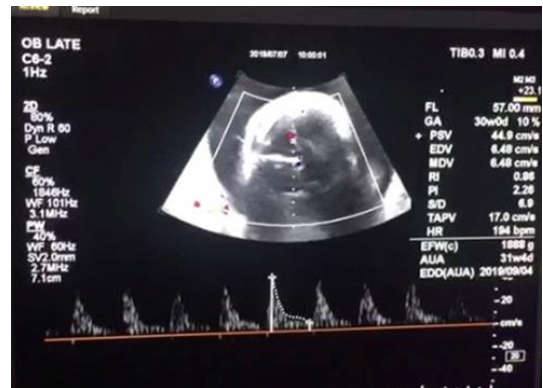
The middle cerebral artery Doppler
